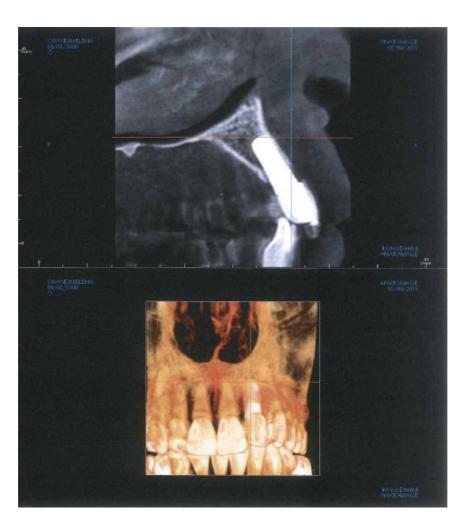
5-year follow-up with CBCT.
